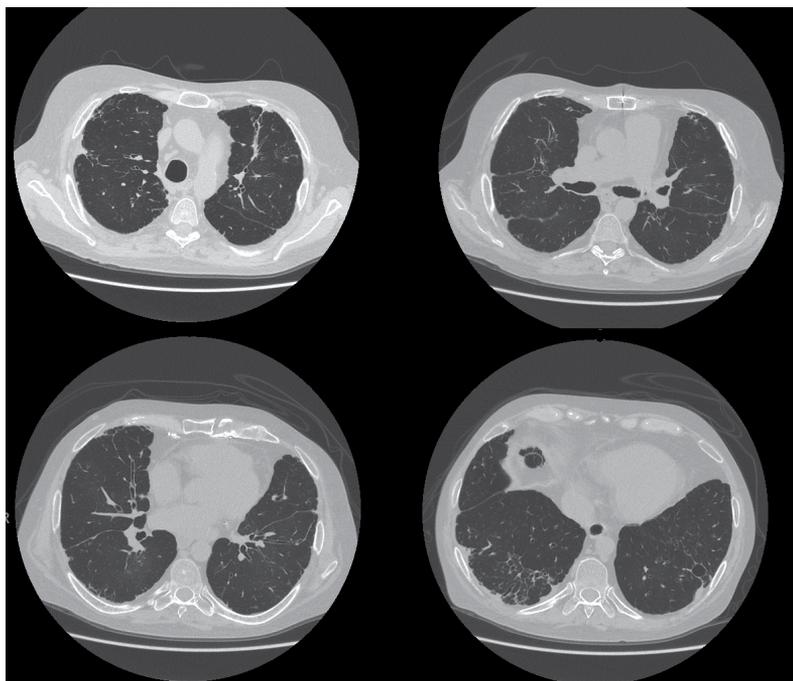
Chest CT scan of a patient with bronchiolitis obliterans syndrome.
